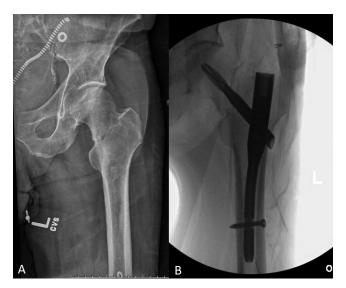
Radiographs showing the left hip (A) at time of fracture; (B) after placement of cephalomedullary nail.
